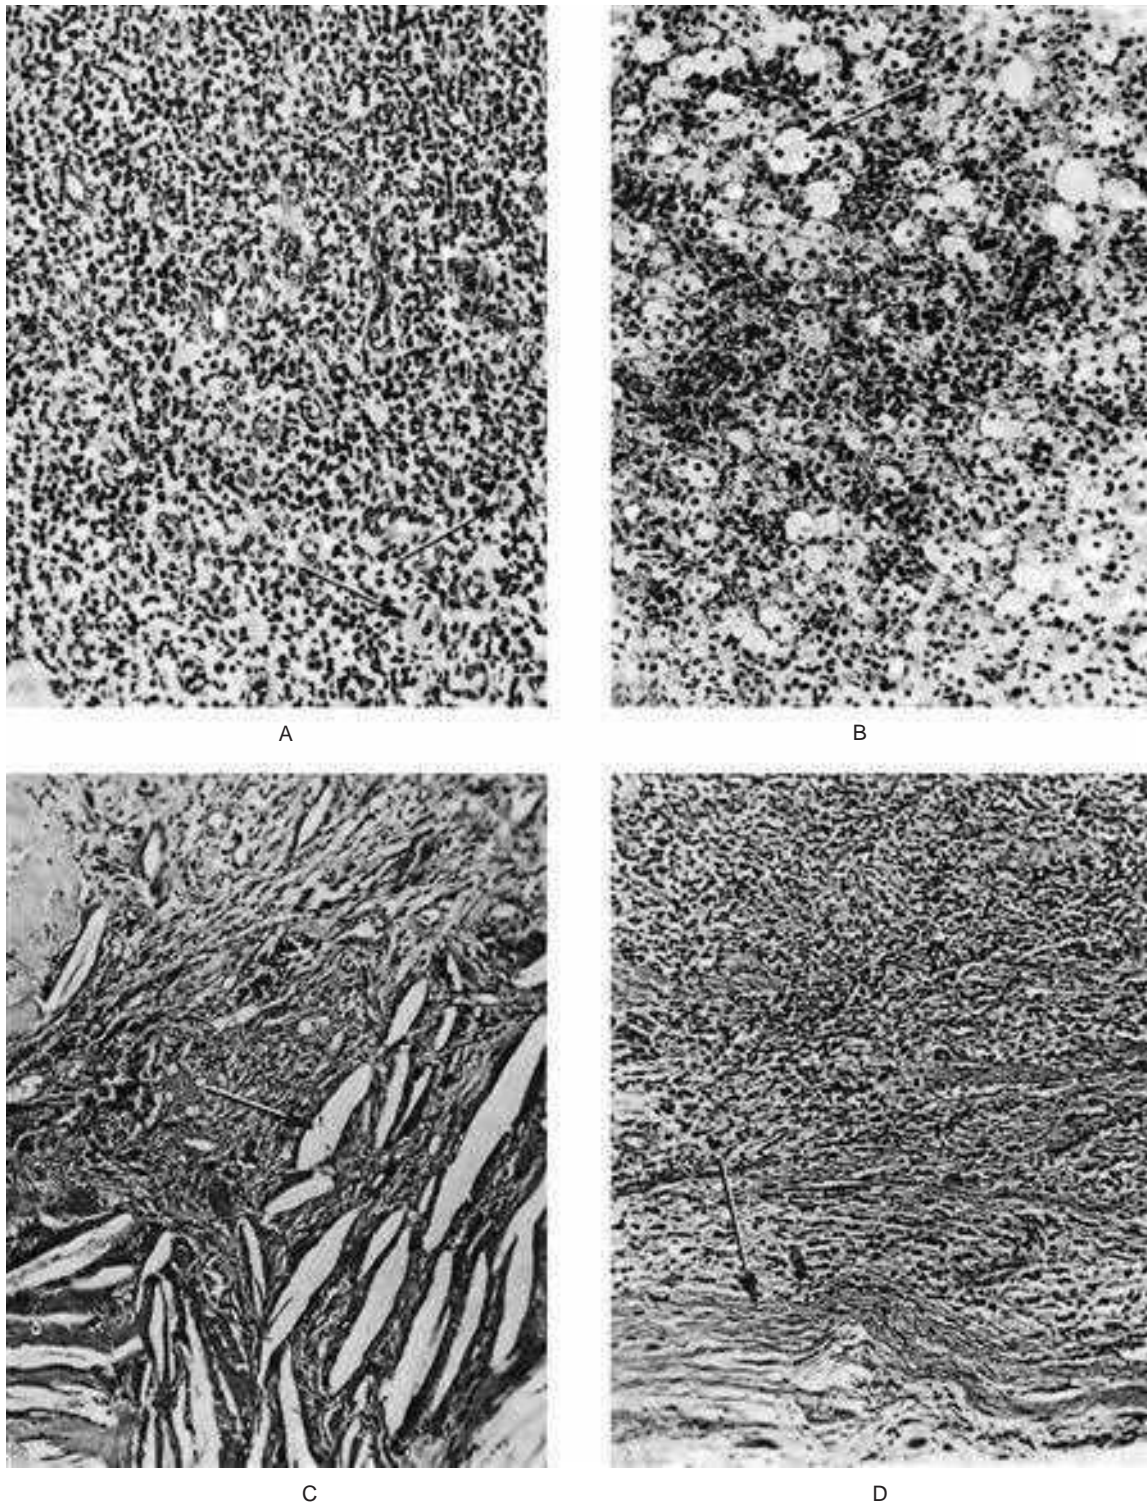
Periapical granuloma.
